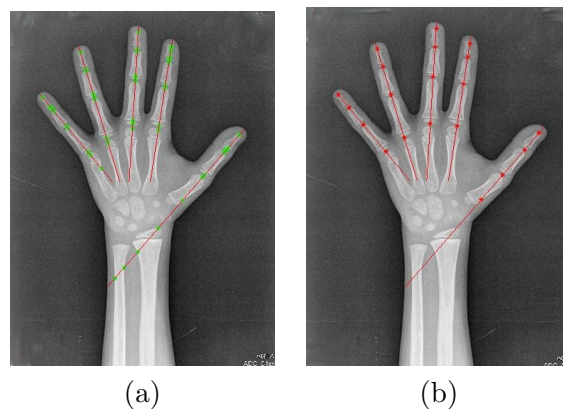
a) Intensity change points along the finger axes; b) Landmarks detected in the example hand radiograph.
